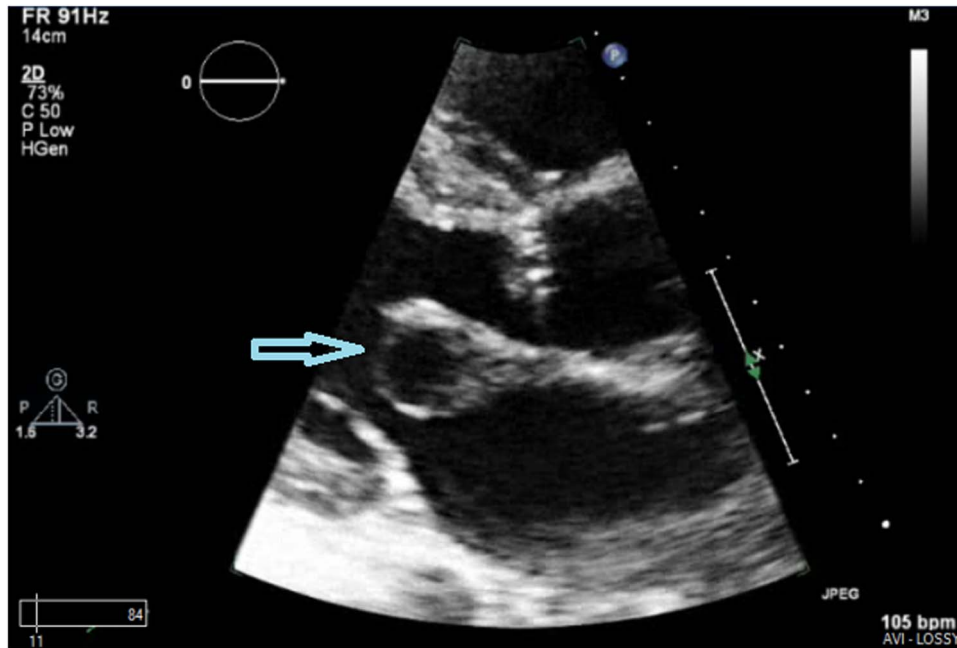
Parasternal long-axis view of the heart on echocardiogram showing the echogenic nodule with a hypoechoic centre on the anterior mitral leaflet.
